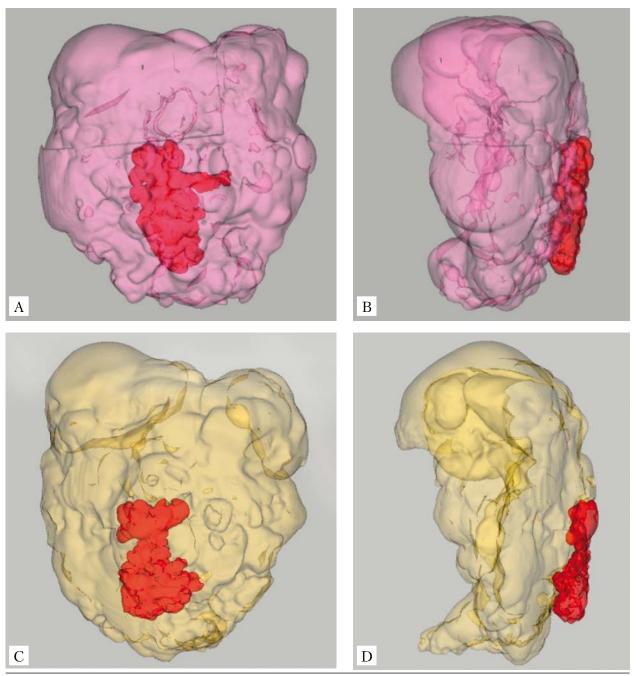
3D modeling of the volumes of the patient's abdominal cavity and hernia sac (marked in red) based on the results of CT. Before BTA injection: direct (A) and side (B) projection; after BTA injection: direct (C) and side (D) projection
